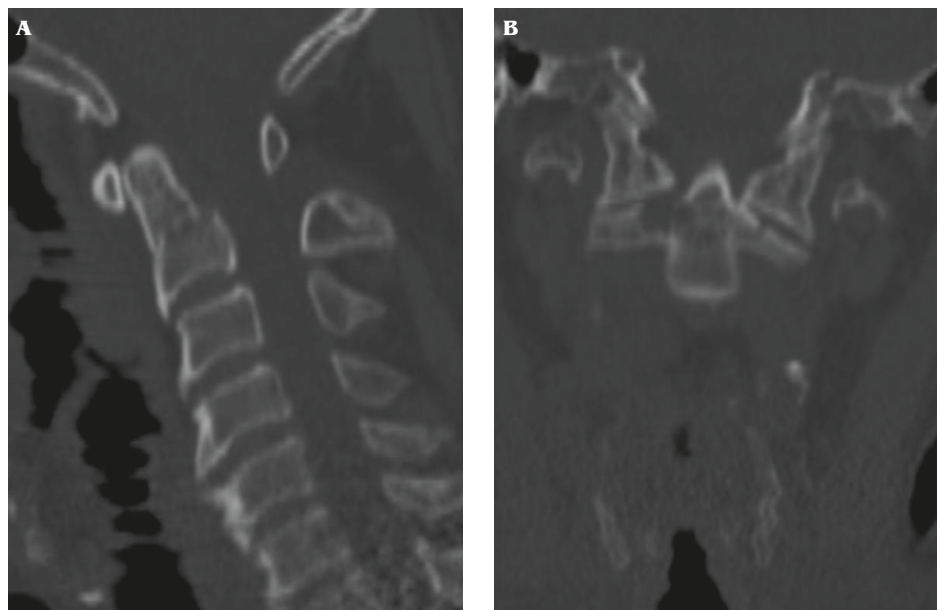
Computed tomography of the cervical spine shows a rostral type III odontoid fracture with mild lateral displacement to the left: (A) sagittal view; (B) coronal view.
